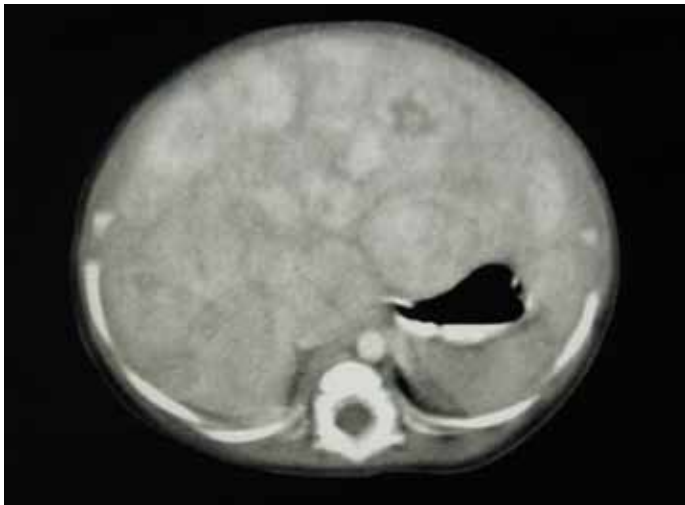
Typical CT scan appearance of large, diffuse infantile hepatic haemangioma, typical of the type associated with cardiac failure, coagulopathy, and life threat.
